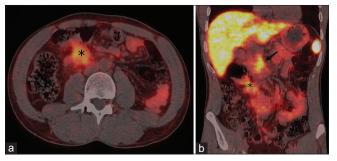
DOTANOC positron emission tomography/computed tomography (a) axial and (b) coronal sections showing intense uptake within the mass (asterisk). Intense physiologic uptake is also seen in the uncinate process of the pancreas (arrow), which is a normal finding
